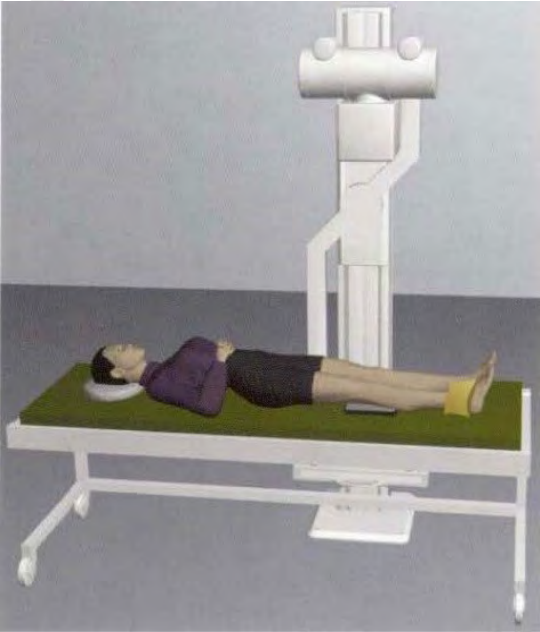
Fundamentals of X-Ray Tube Angulation and Distance
